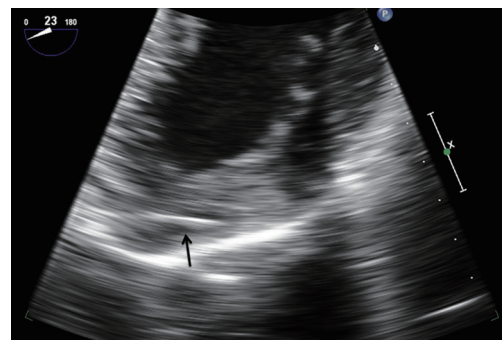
Intraoperative transesophageal echocardiography showed the second needle (arrow) was in the left ventricular myocardium in mid esophageal four-chamber view.
